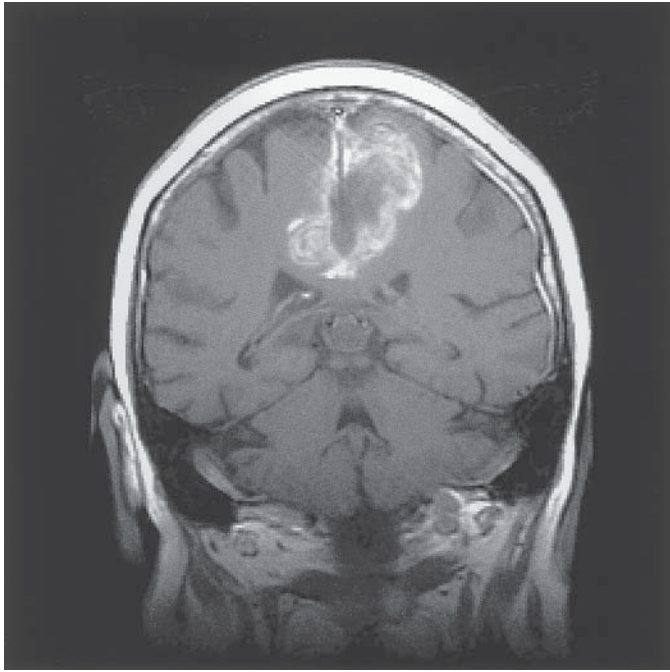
Radionecrosis after radiosurgery. T1 weighted, post-gadolinium MRI scan. Patient with non-small cell carcinoma of the lung, had a single left parasagittal metastatic lesion treated with RS. She required multiple surgical resections of the necrotic tissue and prolonged steroid treatment.
